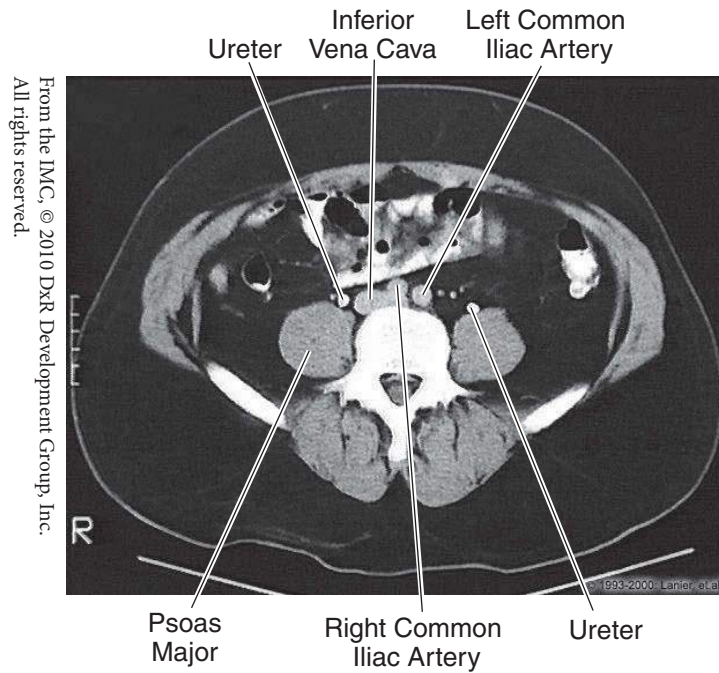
Abdomen: CT, L4
